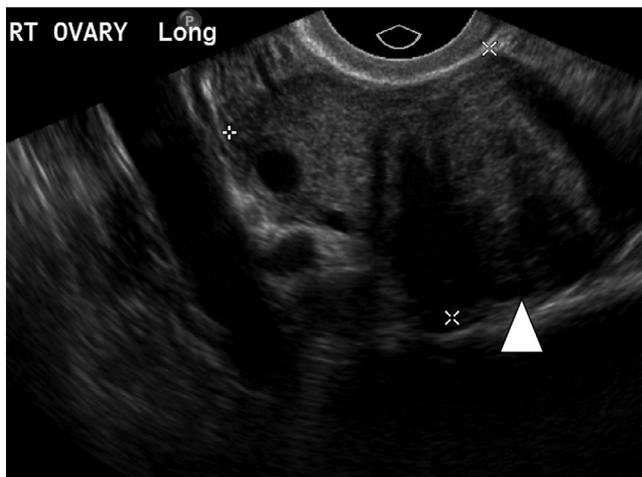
Solid ovarian tumor. Ultrasound image showing a round solid mass with areas of posterior acoustic shadowing (arrow head). Surgical diagnosis was an ovarian fibroma.
